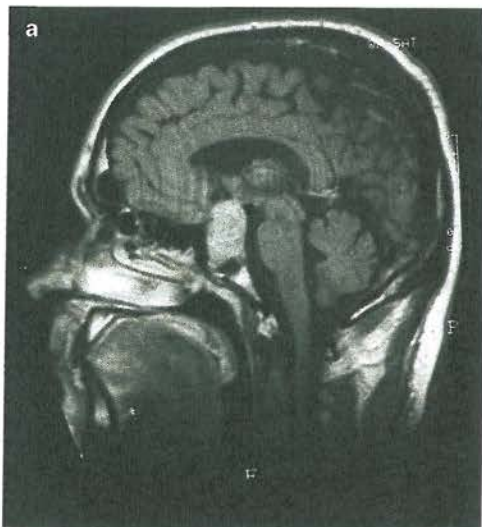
T1-weighted MRI scan showing a pituitary adenoma. (a) Sagittal view; (b) coronal view
